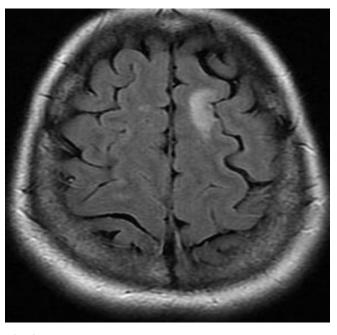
MRI* revealed focal encephalitis and minor cortical hemorrhage.
